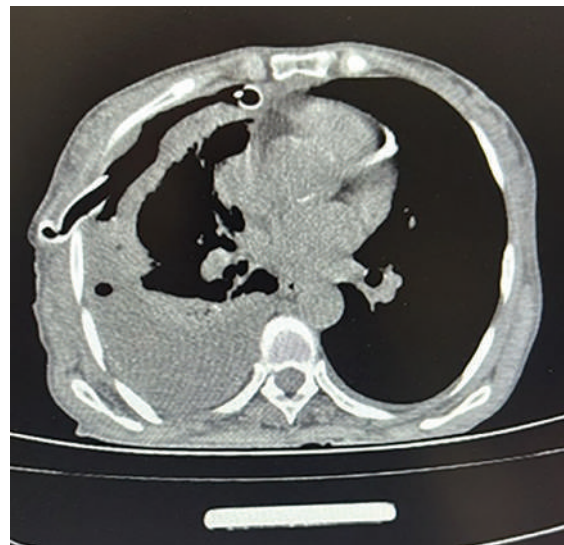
Axial thoracic computed tomography.
